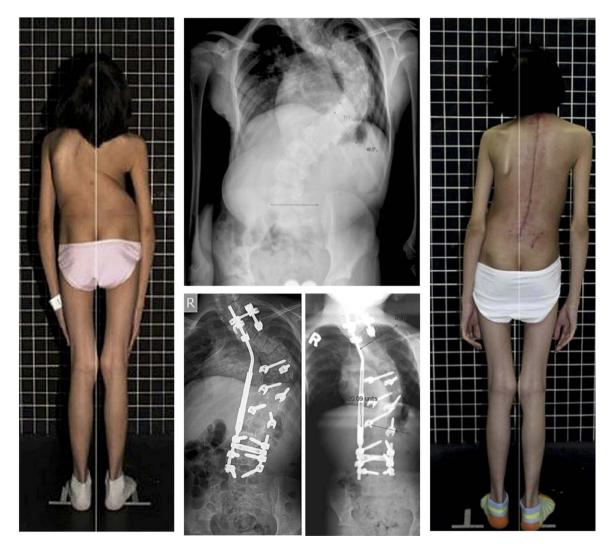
Preoperative photograph of patient with kyphoscoliosis (left). Preoperative standing plain radiograph (top). Immediate postoperative standing anteroposterior radiograph (bottom left). Postoperative anteroposterior standing plain radiograph (bottom right). Postoperative photo of treatment results (right).⁸
